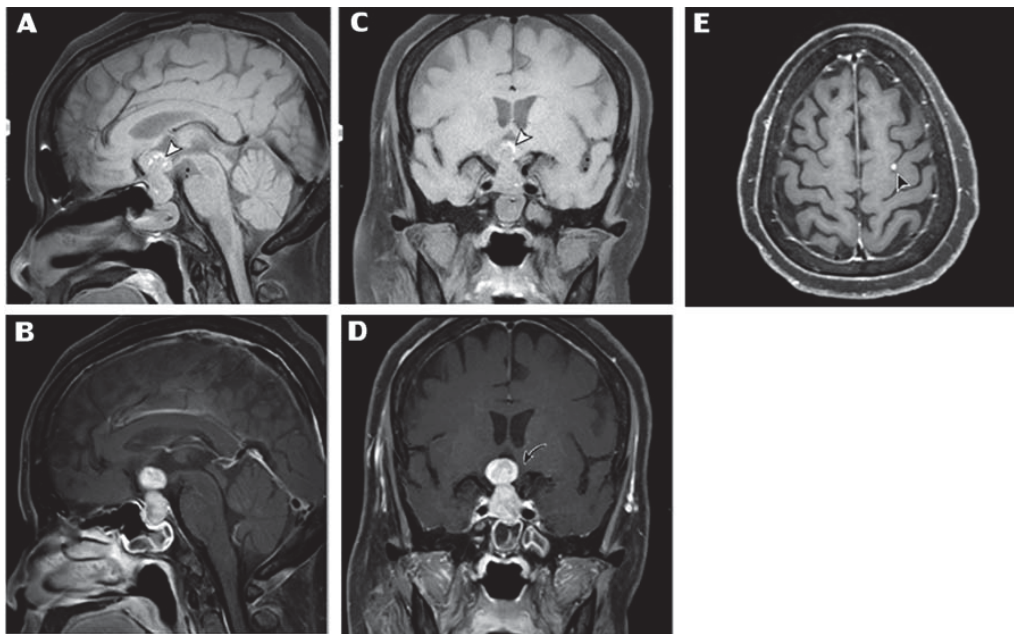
Magnetic resonance imaging, sagittal T1-weighted (T1W) (A), sagittal T1W with contrast (B), coronal T1W (C), coronal T1W with contrast (D), and axial T1W with contrast (E), scans of the patient showing gadolinium-enhanced 1.8x1.9x3.1 centimeters, dumbbell shape, intra-, and suprasellar lesion. Posterior bright spot and pituitary stalk are not clearly seen. The white arrowheads (A&C) indicate hemorrhagic changes within the lesion. Note the optic chiasmal compression by the pituitary metastasis (curve arrow in D). Another small leptomeningeal enhancing nodule at the left-sided precentral sulcus is shown on the axial scan (dark arrowhead in E).
